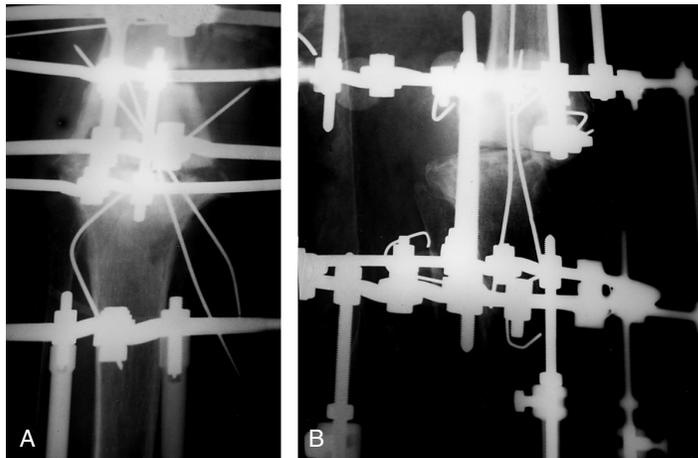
(A) Anteroposterior and (B) lateral radiographs of the same patient showing percutaneous crossed transosseous wires and Ilizarov frame.
